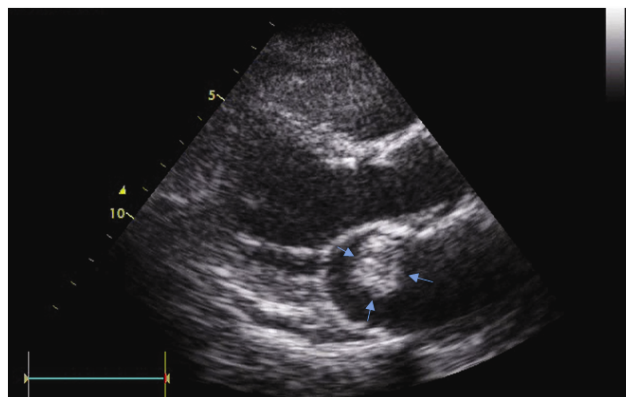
Parasternal long axis view is showing mass in left atrium.
